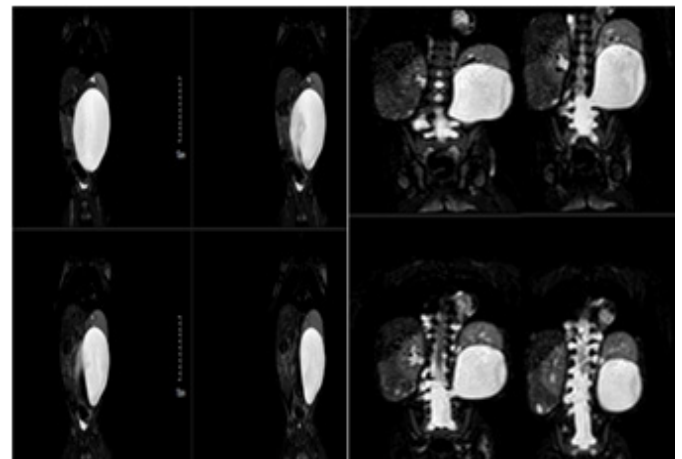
Axial T2-weighted images showing a left-sided hyperintense cystic lesion communicating with the spinal subarachnoid space
